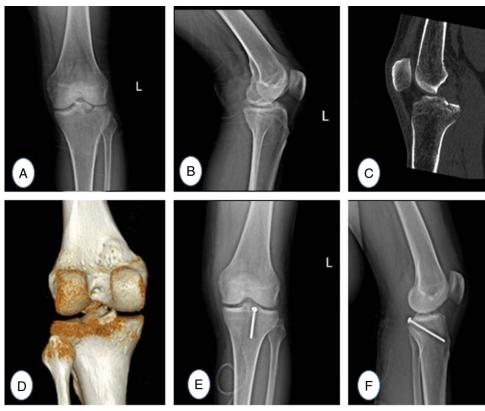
Preoperative X-rays (A, B), preoperative computed scan (C, D), and early postoperative X-rays (E, F).
